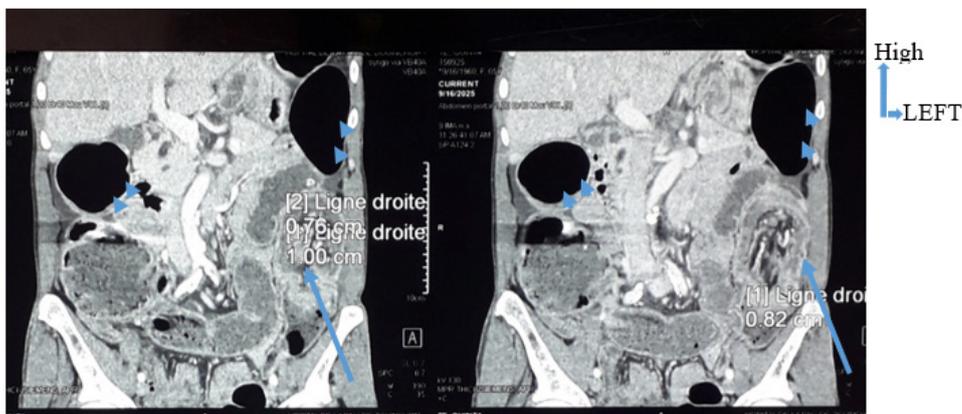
frontal section of abdominal CT scan showing acolonic distension (arrowhead), with thickening of the wall and a roll of colonic intussusception (arrow).
